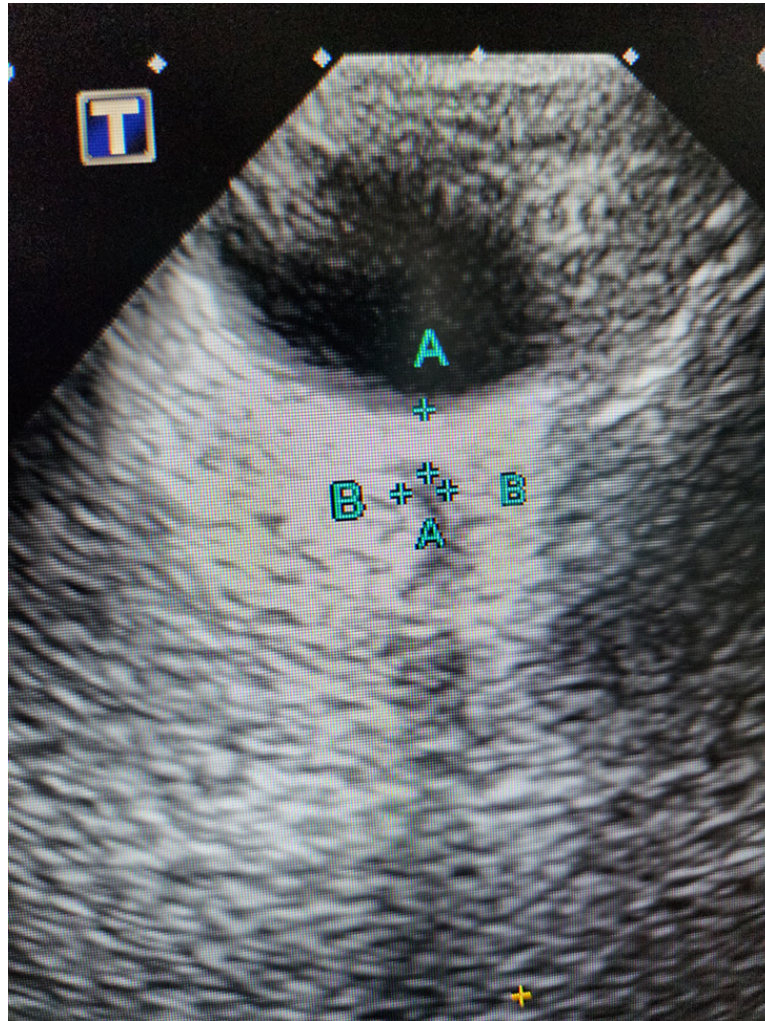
Optic nerve sheath ultrasound measurement by application of a linear probe placed transversally over the closed eyelid of the patient then measuring at 3 millimeters from the globe when the diameter is greater than 0.5 centimeter, it correlates with ICP greater than 20 mmHg (A = Eye globe and B = Optic nerve sheath).
